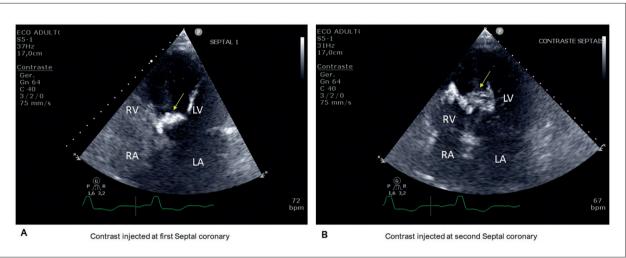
Images using echocardiography enhanced agent (SonoVue) injected at first septal coronary (Panel A) and second septal coronary (Panel B). Once the perfused myocardial area from the second septal coronary was larger and involved the RV's moderator band, the decision to occlude the first septal coronary was taken. RA: right atria; LA: left atria; RV: right ventricle; LV: left ventricle.
